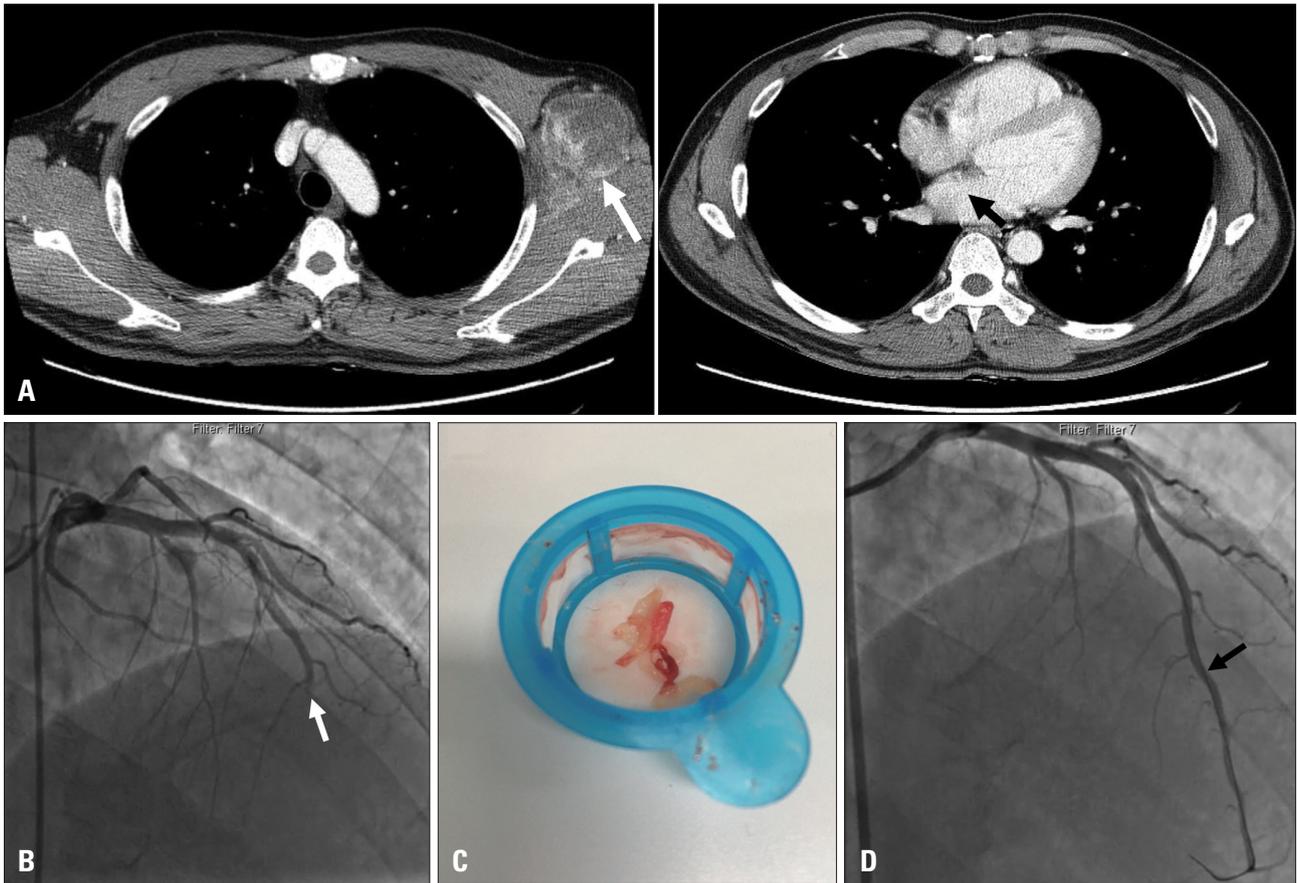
Computed tomography and coronary angiography. A: Initial chest computed tomography showed a large, infiltrative, and heterogeneously soft tissue mass at the left axilla (white arrow). There was no definite mass in the left atrium (black arrow). B: Coronary angiography showed the total occlusion of the distal left anterior descending artery (white arrow). C: The aspirated tissue material appeared as mucoid and whitish debris. D: The final coronary angiography showed that flow had been completely restored (black arrow).
